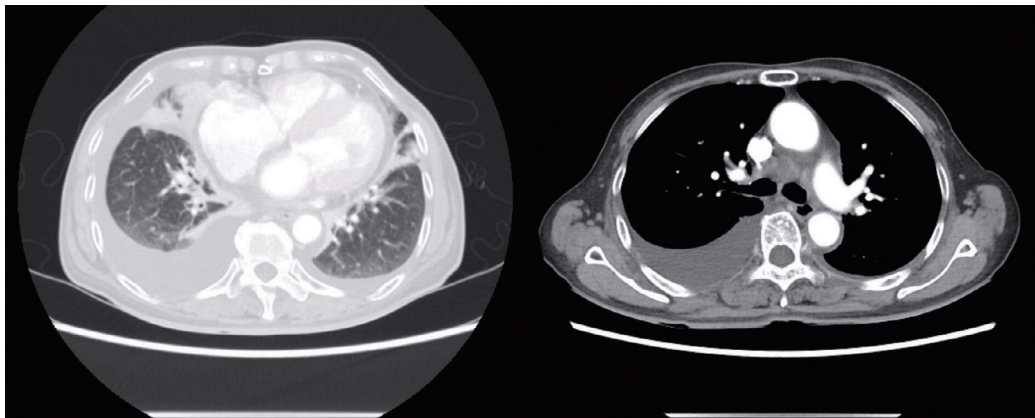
Chest CT revealed bilateral lung consolidation, interlobular and septal thickening, an enlarged mediastinal lymph node and bilateral pleural effusion.
